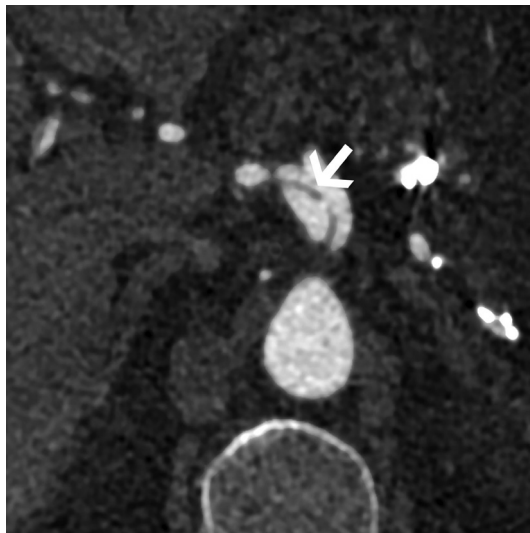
CTA image of CA aneurysm with dissection (indicated between the black arrows).
